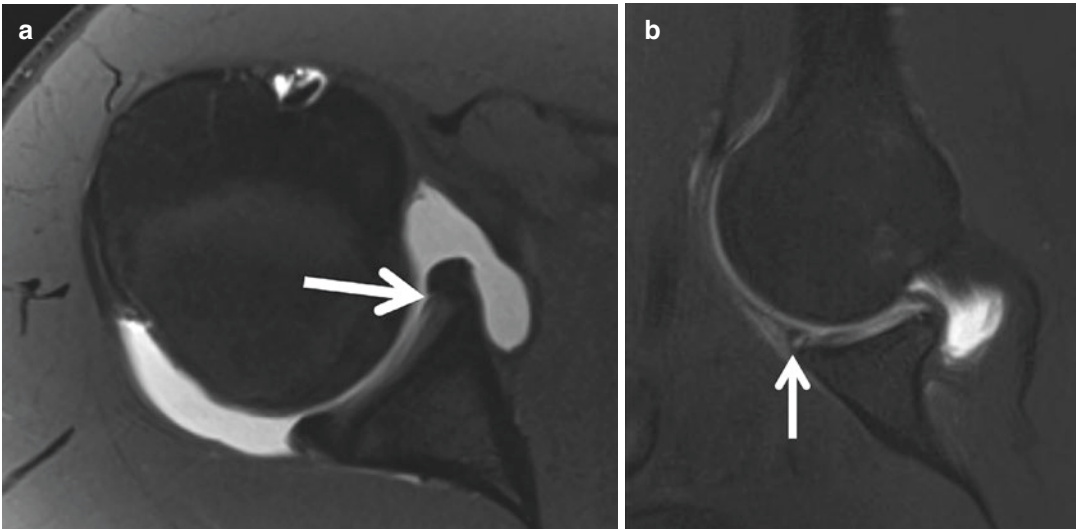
Anteroinferior labral tear on direct MR arthrography. (a) Axial T1-weighted fat-suppressed image from a direct MR arthrogram demonstrates a normal-appearing labrum without contrast imbibition
